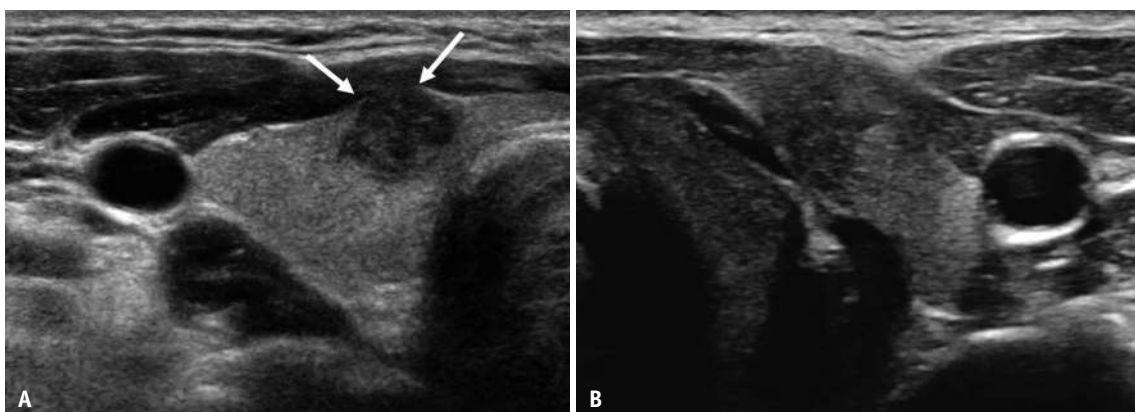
Ultrasonography features of extrathyroidal extension of thyroid cancer beyond the anterolateral thyroid capsule.
